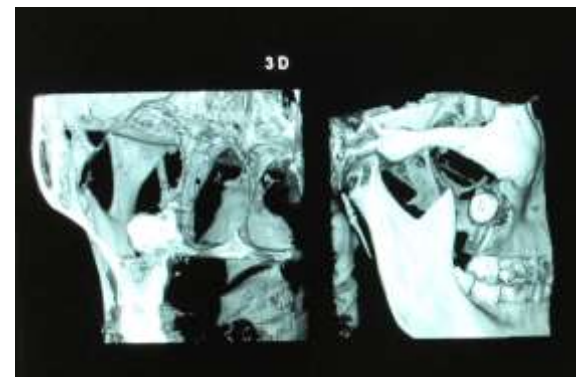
3D reconstruction CBCT
